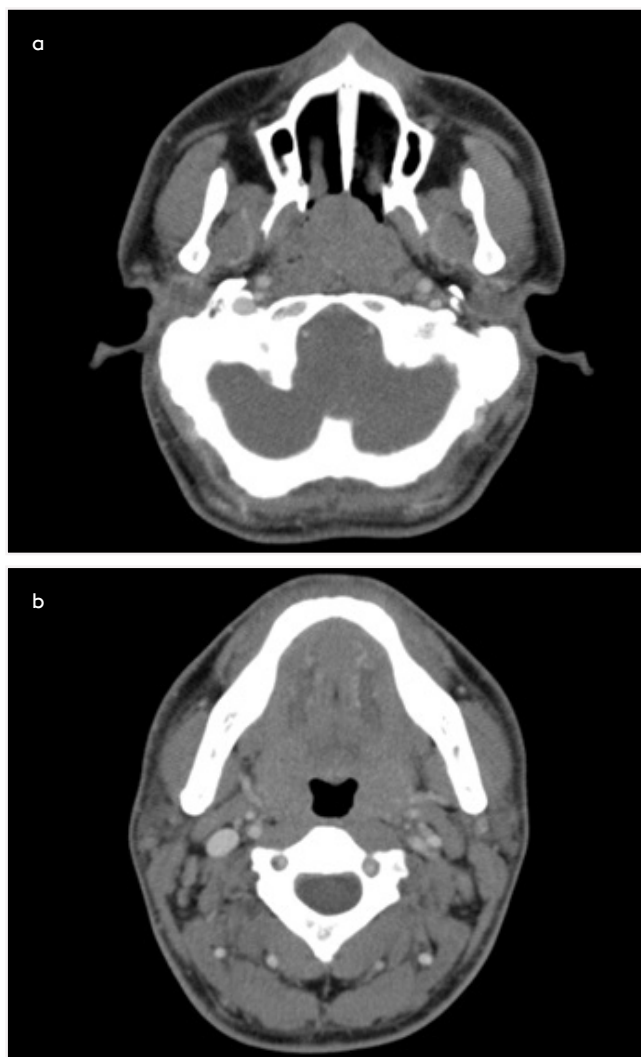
a, b. A 36-year-old male patient with primary EHNHL (HL, Lymphocyte rich type lymphoma, stage IE) in Waldeyer's ring, received chemoradiotherapy and disease free more than 2 years. Axial contrast-enhanced CT images (a and b) show well-defined, regular shaped, mildly homogeneous enhanced mass affected bilateral tonsils, nasopharynx and base of tongue.
